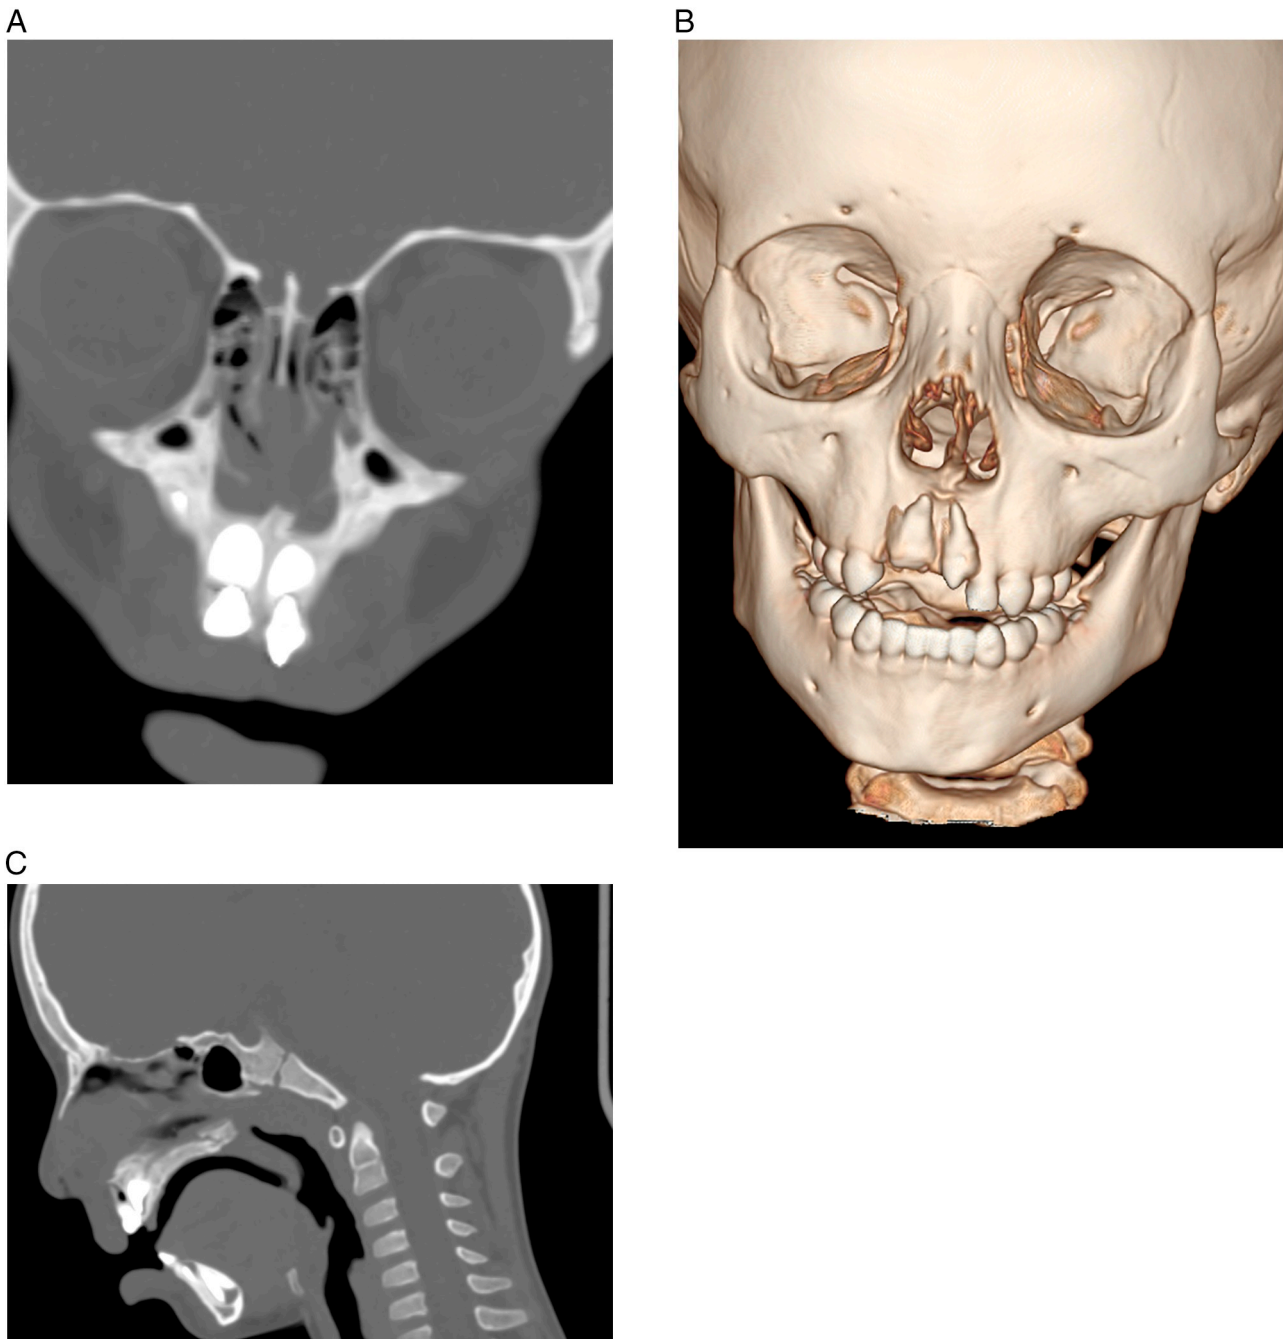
CT images showing intrusion of primary central incisors (Fig. 2a and b - 3D volume rendered image); A fracture of hard palate was also noted (Fig. 2c).
